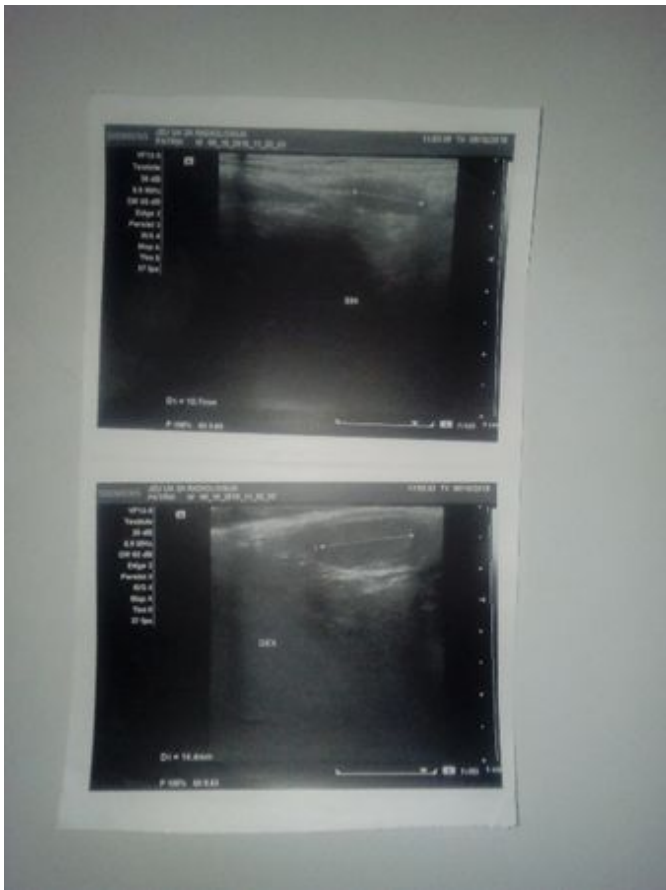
Pictures from ultrasound scanning of the testicles before surgery.
